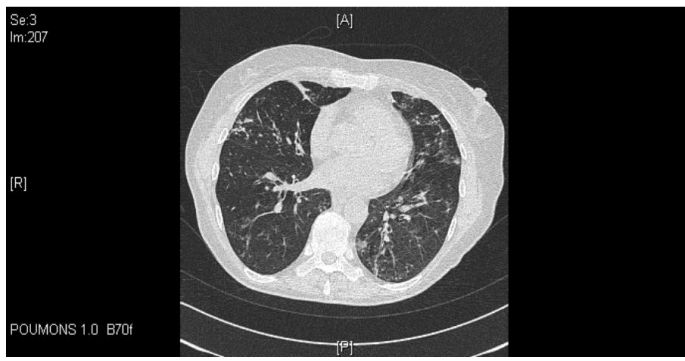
Initial CT-scan of the chest showed predominantly an aspect of bronchiolitis associated with an emerging aspect of focal lung condensation.
